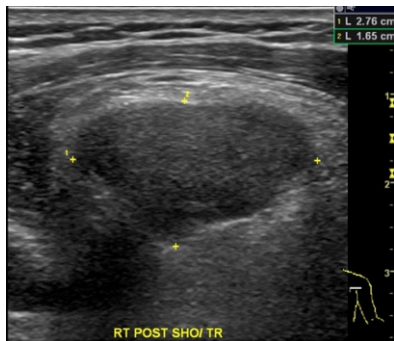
Chondrolipoma in the scapula of a 62-year-old woman. Sonogram displayed a well-demarcated, homogenous hypoechoic lesion at the muscle layer of the right posterior shoulder, approximately 2.76x1.65 cm in size.
